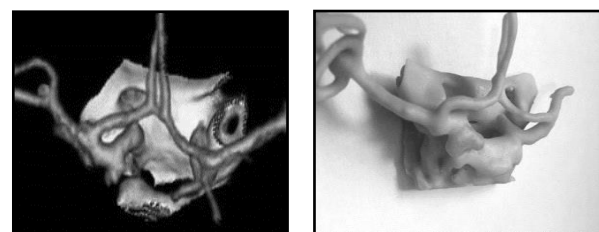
3D Angio CT vascular tree and aneurysmal lesion and 3D printed models
